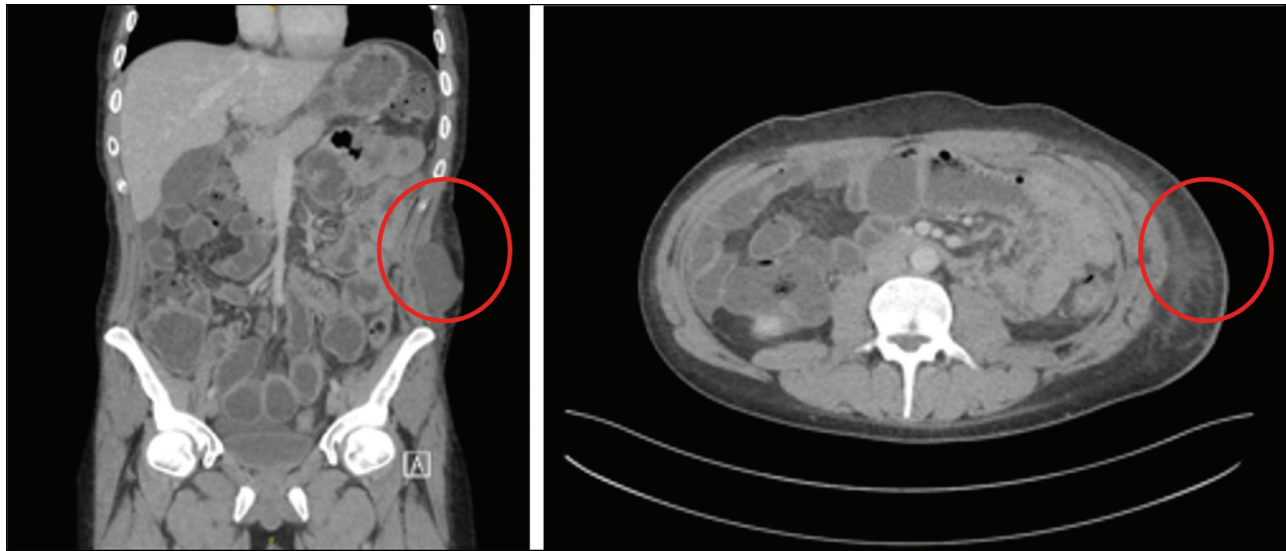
Postoperative CT with IV contrast (with hematoma): post-left lumbar hernia/lateral abdominal wall hernia repair with subcutaneous fluid collection along the lateral abdominal wall; otherwise, no recurrence of hernia
